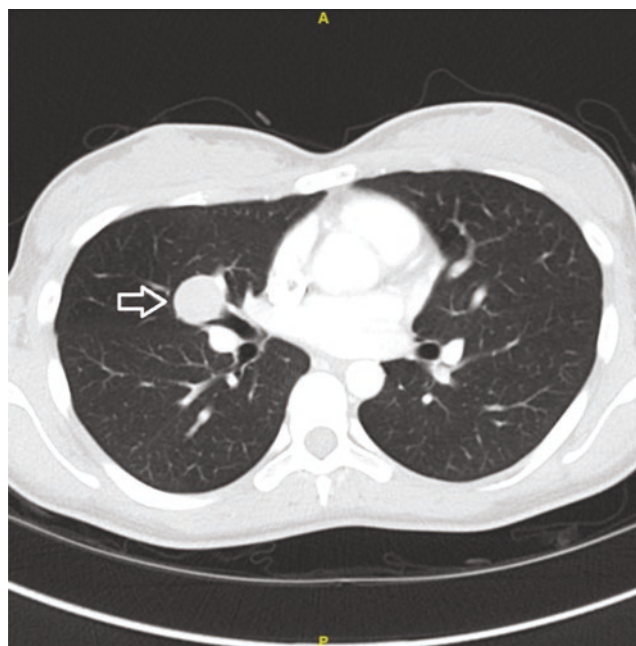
Axial chest computed tomography shows a 2.0 cm, well-circumscribed mass in the right middle lobe (arrow)
